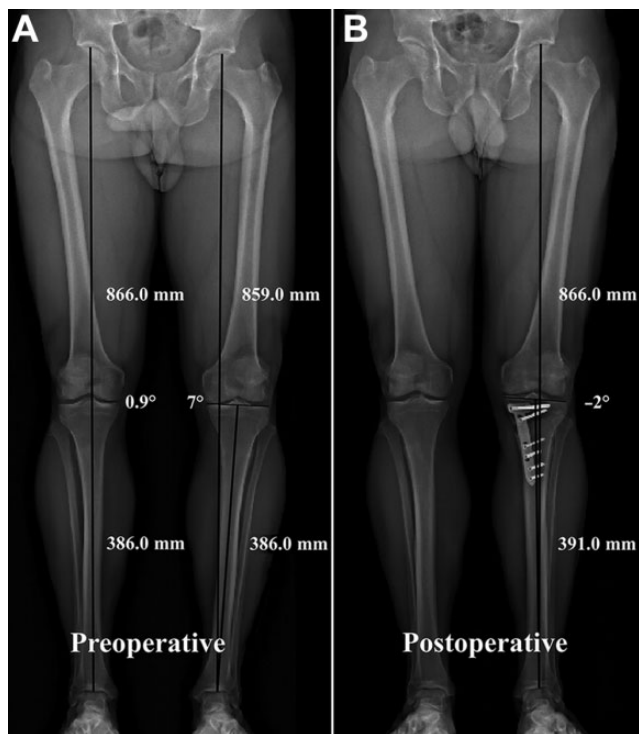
(A) Preoperative and (B) postoperative measurements of the lower limb mechanical axis, full leg, and tibial length standing anteroposterior radiograph. This patient had a preoperative lower limb discrepancy of -7 mm and a preoperative mechanical axis of the involved leg of 7° varus compared with 0.9° of varus on the contralateral side. Postoperatively, the mechanical axis was corrected to 2.2° of valgus, resulting in restored native lower limb length.
